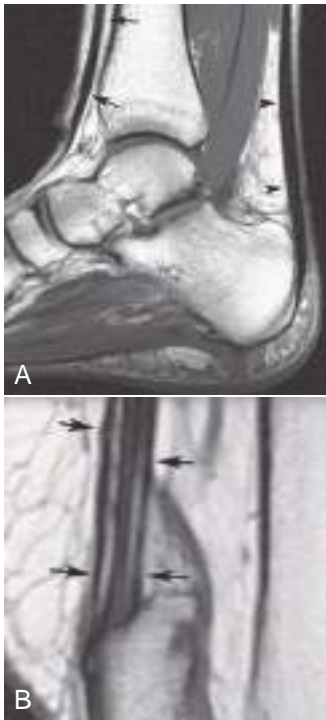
Normal tendons on MRI. (A) Normal tendons have low signal intensity on all MRI sequences, with a few specific exceptions. Sagittal T1-weighted MR image of the ankle and hindfoot shows normal Achilles (*arrowheads*) and tibialis anterior (*arrows*) tendons. (B) As shown in this sagittal T1-weighted MR image, one exception is the distal quadriceps tendon, which is formed from four muscles in three layers (*arrows*).
